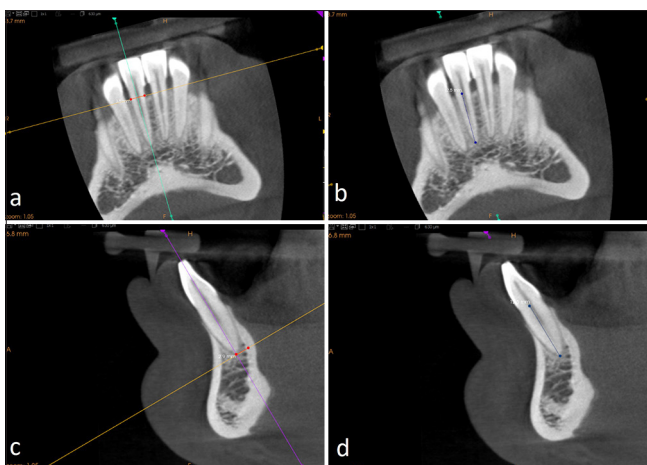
Tracing with CBCT software measuring tool on (a and b) sagittal and (c and d) coronal.
